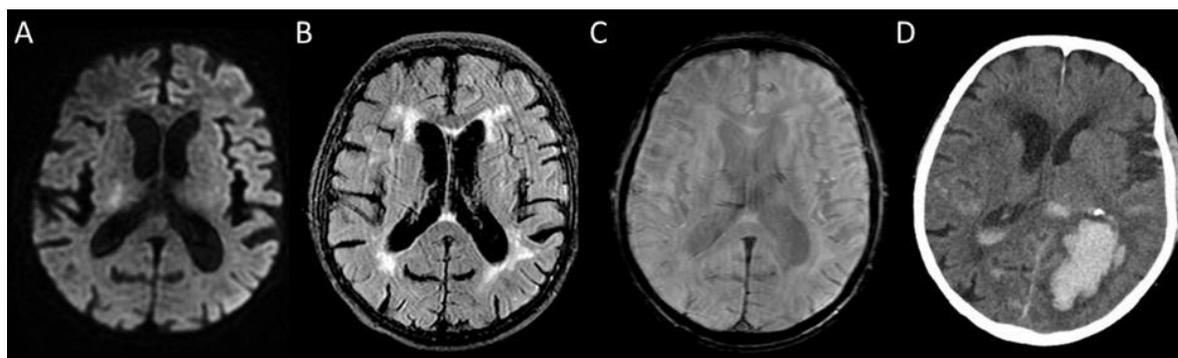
Pre-thrombolysis MRI and 24-hour post-treatment CT of the patient with sICH. A) DWI demonstrating a right hemispheric lacunar infarct. B) No corresponding hyperintensity is visible on FLAIR. Periventricular white matter hyperintensities indicate small vessel disease. C) No microhaemorrhage was detected on SWAN. D) 24-hour repeat CT shows a remote, left parieto-temporo-occipital haemorrhage with perifocal oedema, mass effect, and propagation into the lateral ventricles.
